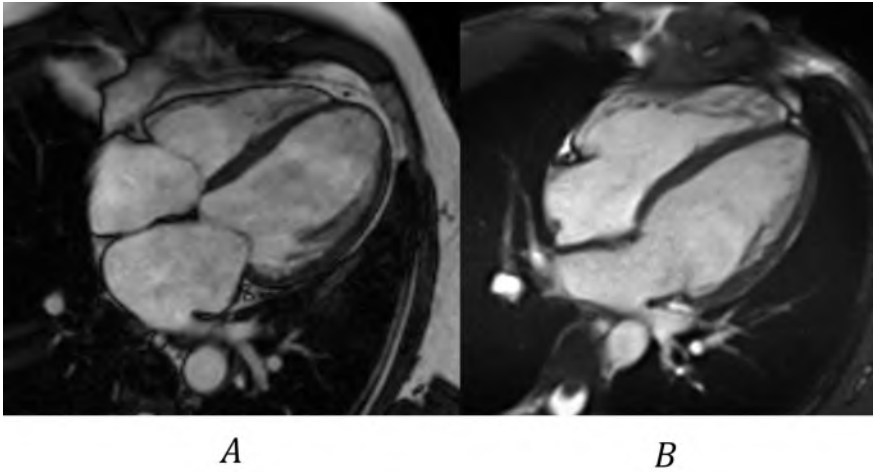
Example frames and comparison of cardiac MRI sequences of the 4 chambers view. A) Healthy subject. B) Subject with a chronic infarction, akinetic apex and transmural scar. Additionally, mitral regurgitation is observed. Adapted from https://commons.wikimedia.org/wiki/File:4-CH_cine_normal.gif and https://commons.wikimedia.org/wiki/File:4CH_cine_infarct.gif. By Doregan [CC BY-SA 4.0 (<https://creativecommons.org/licenses/by-sa/4.0>)].
